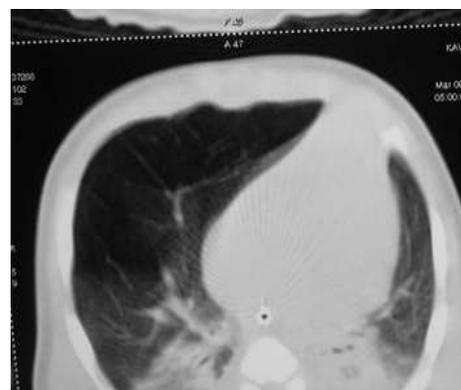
CT chest - right middle lobe emphysema with attenuation of vascular markings and compression of lower lobe and herniation of emphysematous lobe.
